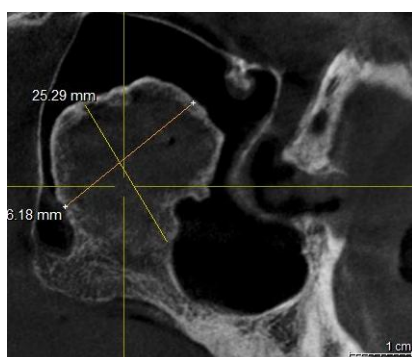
12 months post-operative CBCT with bone fill of the cystic site
